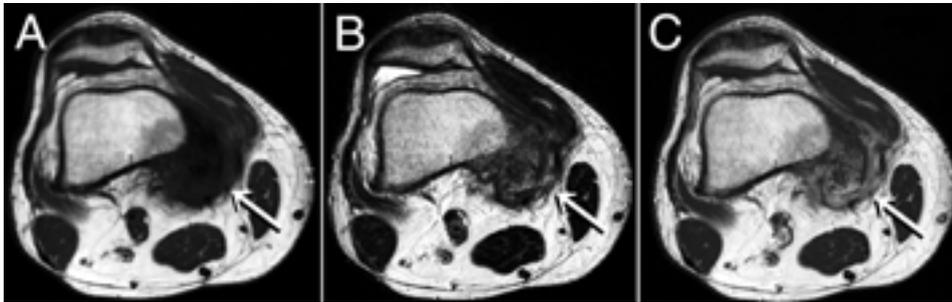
Magnetic resonance imaging demonstrated a femoral lesion (arrow) with low signal intensity on T1 weighted image (A), heterogeneous intensity on T2 weighted image (B) in the tumor. The tumor and the surrounding soft tissues were enhanced after administration of paramagnetic contrast medium (C).
